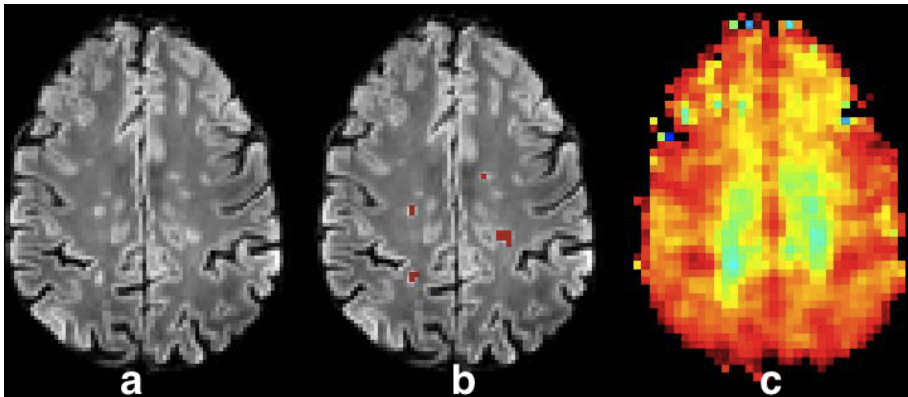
(a) Bias corrected FLAIR image followed by (b) overlaid lesion segmentation from an automated method, and (c) the acquired myo-Ins map. The myo-Ins concentration increases from red to blue. The MRSI map of the myo-Ins shows more extent of pathological changes in white matter compared to the conventional FLAIR MRI [111, 166].
